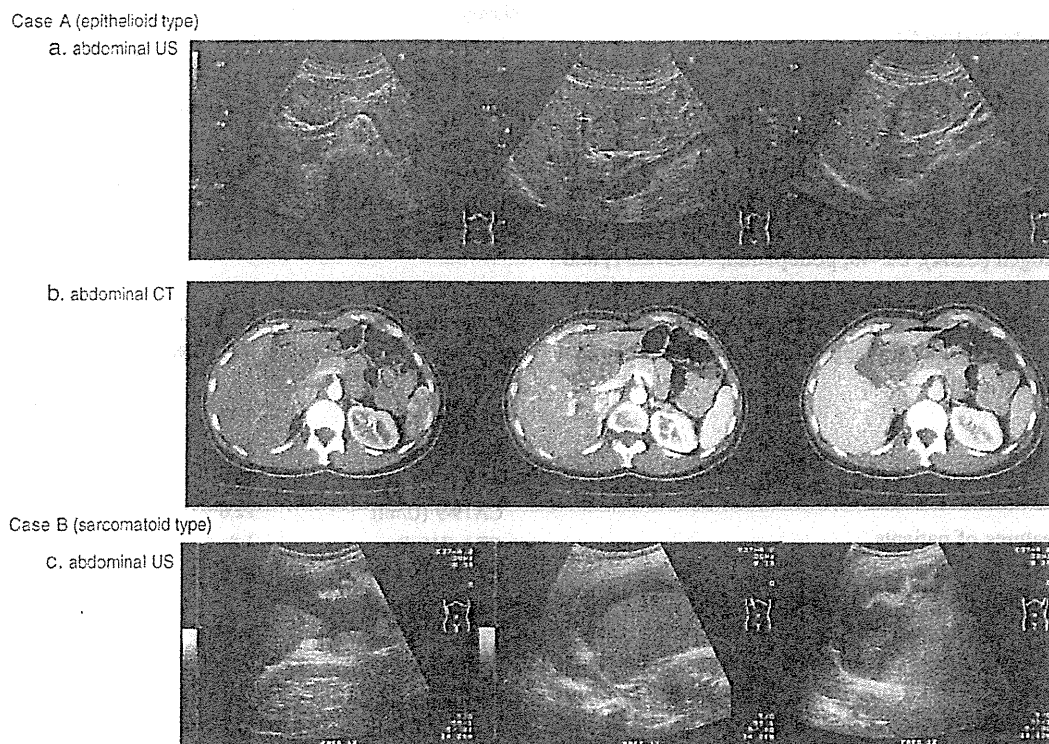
Abdominal imaging in cases *A* and *B*. a 43-year-old woman with epithelial-type malignant peritoneal mesothelioma (*localized MPEM*). Abdominal ultrasound shows a round-shaped mass located near the hilum of the liver (*case A*). b Axial view of abdominal CT scan
